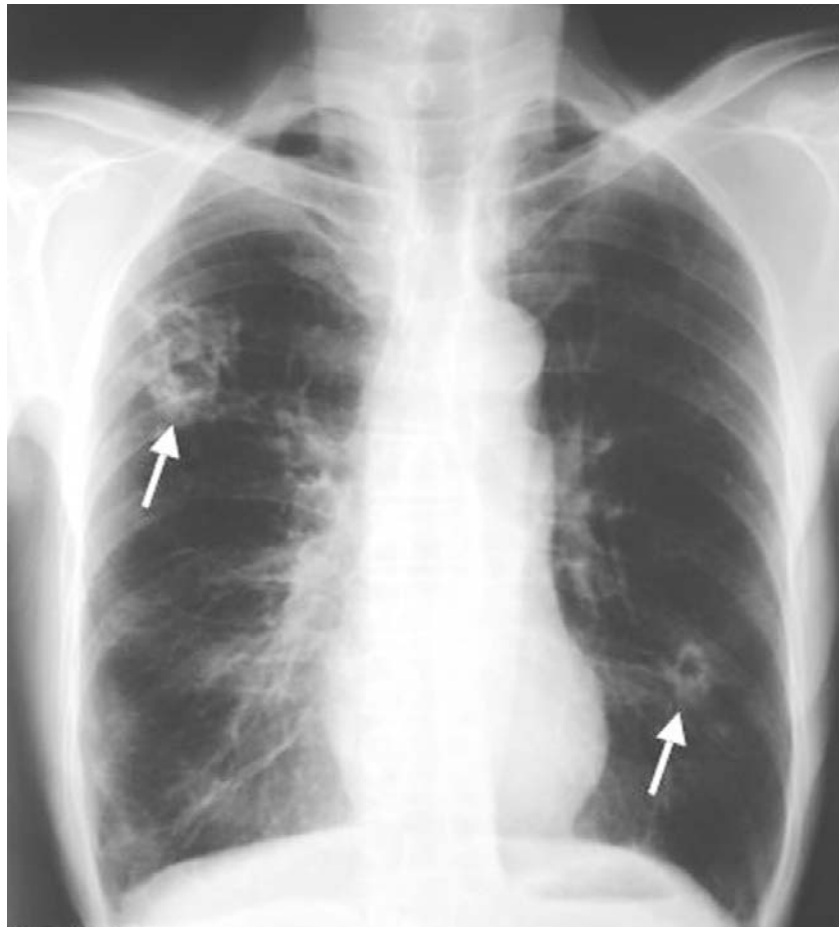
Chest radiograph showing typical cavitating lesions caused by *Paragonimus westermani* infection. The patient ate sashimi of wild boar meat ~2 months before onset of the disease.
